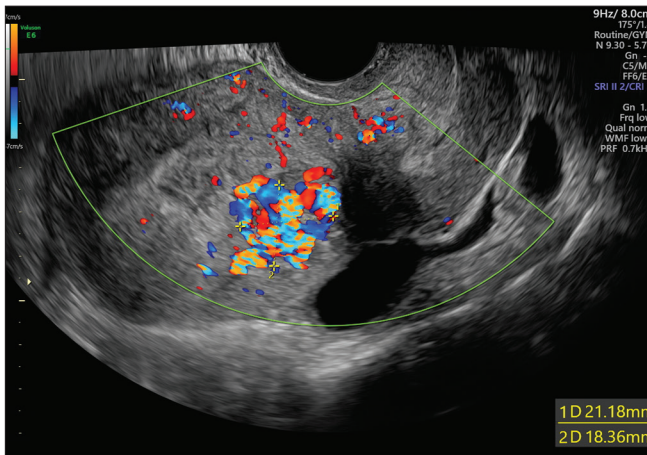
Color Doppler ultrasound sagittal view of the uterus with turbulent flow and aliasing creating a mosaic pattern
